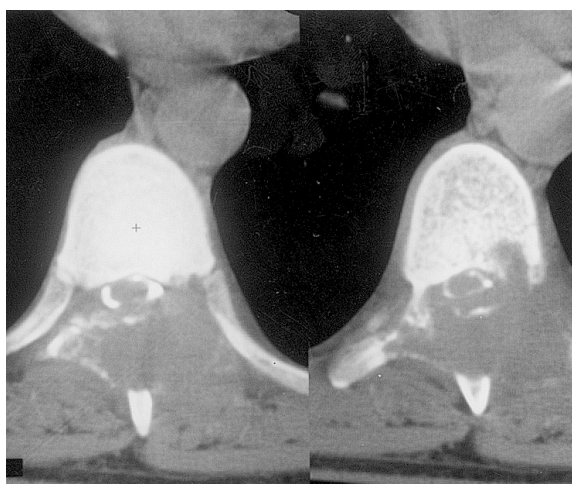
Same patient as in Fig. 3. 33-year-old woman with metastatic paraganglioma. Axial CT scans taken following myelography show an expansile osteolytic lesion involving the posterior elements of T8 vertebra, with an associated extradural mass compressing the thecal sac. Emergency laminectomy and tumour excision were subsequently performed.
